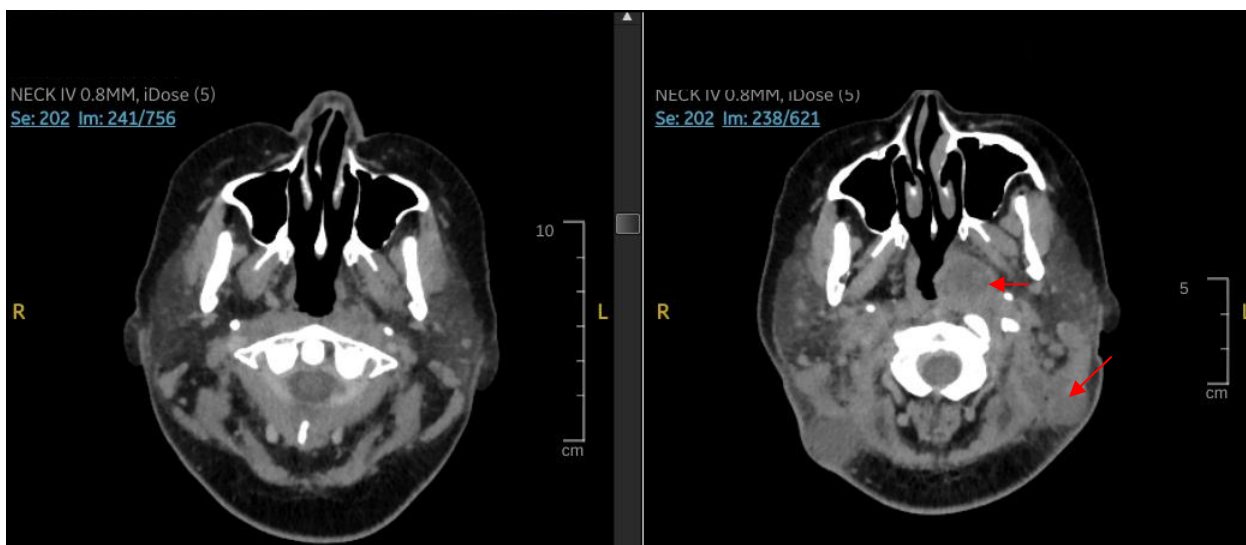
Axial view CT neck at the level of nasopharynx, hypodense collection in the left lateral nasopharyngeal wall in close proximity to the left eustachian (right), a finding which was absent in the earlier scan (left)
